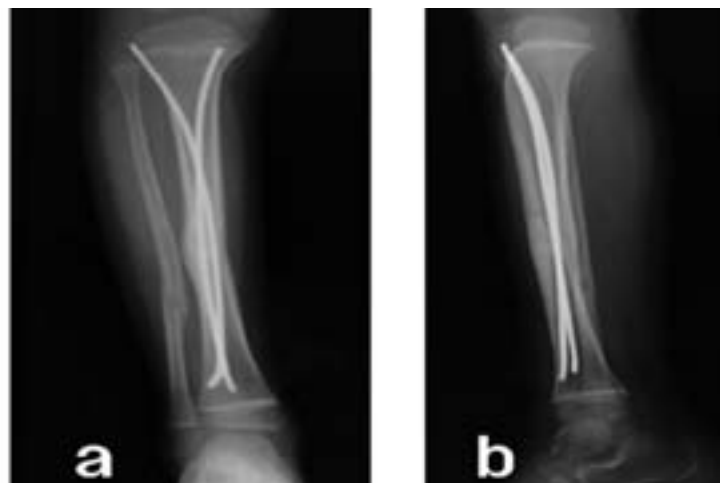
a, b – X-ray image of 6 weeks post-operative antero-posterior and lateral view
